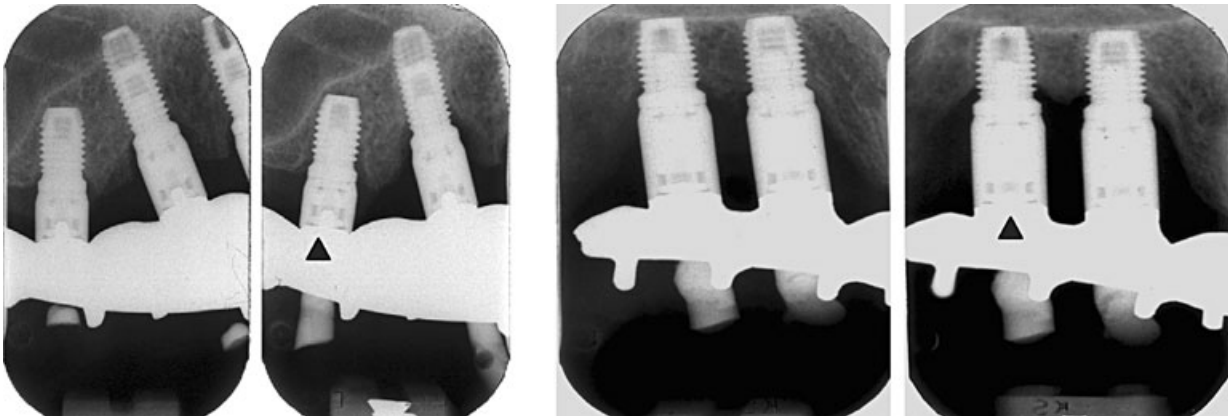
Notice the very subtle sign, a thin radiolucent zone around the implants, indicating that the implants marked by arrows are not osseointegrated. Comparison of the radiographs with those taken earlier, the ones to the left in each image pair, makes the detection of subtle signs much easier.
